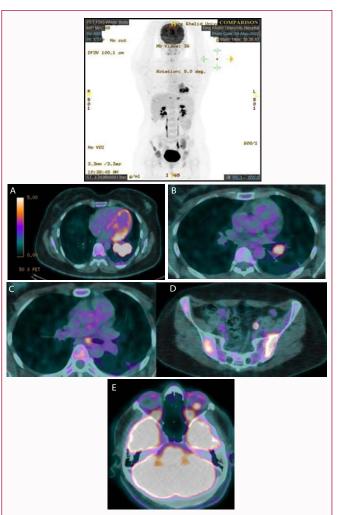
A) FDG-avid left lower lobe mass, SUVmax 16.4, with extension to the left hilum inferiorly, SUVmax 8.8. B) Mildly FDG-avid rounded atelectasis in left lower lobe. C) Small focus of FDG uptake in the left subcarinal region, likely lymph node, SUVmax 5.5. D) Multiple foci of uptake in the bone marrow with no corresponding osseous lesions. E) Small focus of FDG uptake in the posterolateral aspect of the left ocular globe, corresponding to the lesion seen on MRI, SUVmax 7.6.
